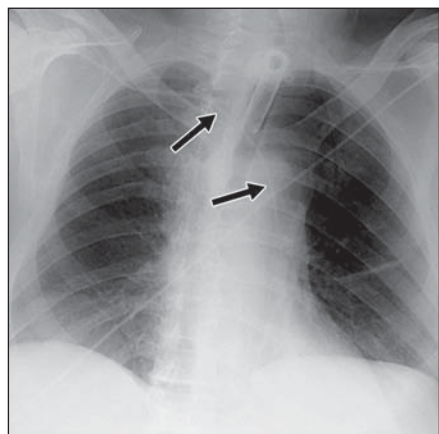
58-year-old woman with misplaced central venous catheter in pericardiophrenic vein. Magnified anteroposterior chest radiograph shows left internal jugular catheter (*arrows*) coursing along left cardiac border, consistent with placement in pericardiophrenic vein.
